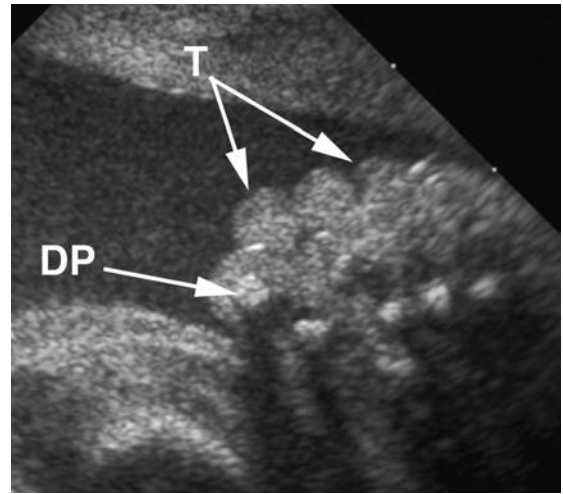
Axial sonogram of the fetal toes (T) demonstrating the soft tissues. Little bony structure is seen, although the distal phalanx (DP) of the great toe is visible.
